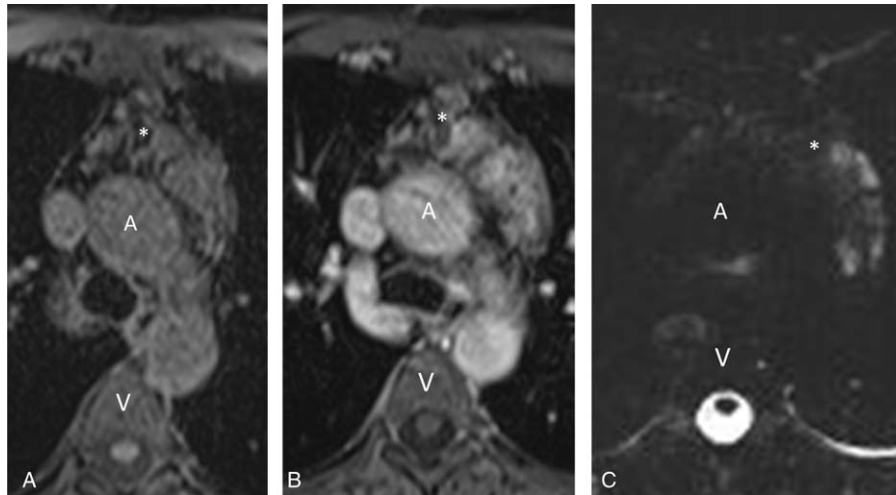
Axial MR images in a 33-year-old patient with an anterior mediastinal microcystic venolymphatic malformation. Axial T1-weighted pre (A) and postcontrast (B) MR images demonstrate a mass (*) in the anterior mediastinum that is isointense to adjacent mediastinal structures and enhances with contrast on delayed phased images. C, T2-weighted MR images demonstrate several small cystic components that do not exceed 2 cm in size. Findings are consistent with microcystic venolymphatic malformation. (A = ascending aorta, V = vertebral body).
